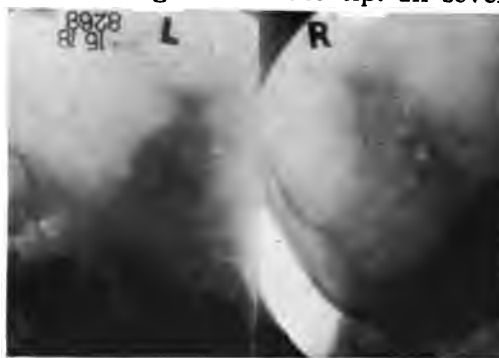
ROENTGENOGRAM OF SKULL NO. 36 SHOWN IN FIGS. 5 AND 6.
